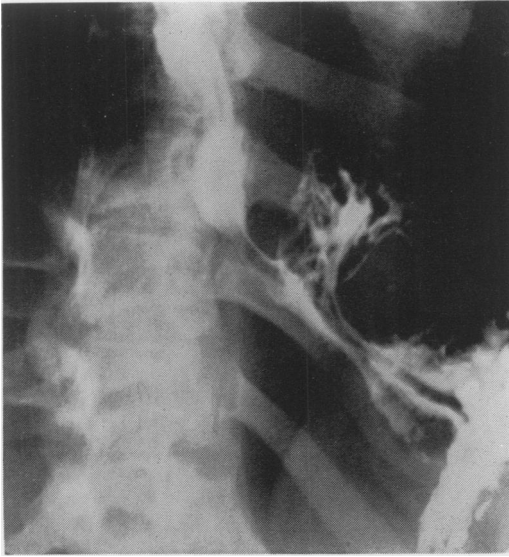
Postoperative roentgenogram made two months following a Heller operation. There is a large hiatus hernia at gastro-esophageal area.
